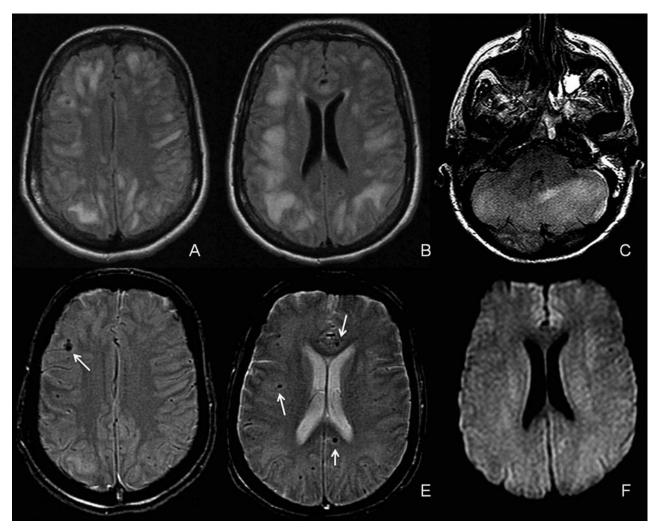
Case 1. (A, B, and C) Extensive pattern of abnormal increased signal intensity on FLAIR sequence in multiple locations in the brain and cerebellum, most notably in subcortical white matter. (D and E) Echo gradient sequence showing areas of petechilal bleeds (*white arrows*). (F) These areas did not demonstrate restricted diffusion on B1000 MRI sequence (F).
